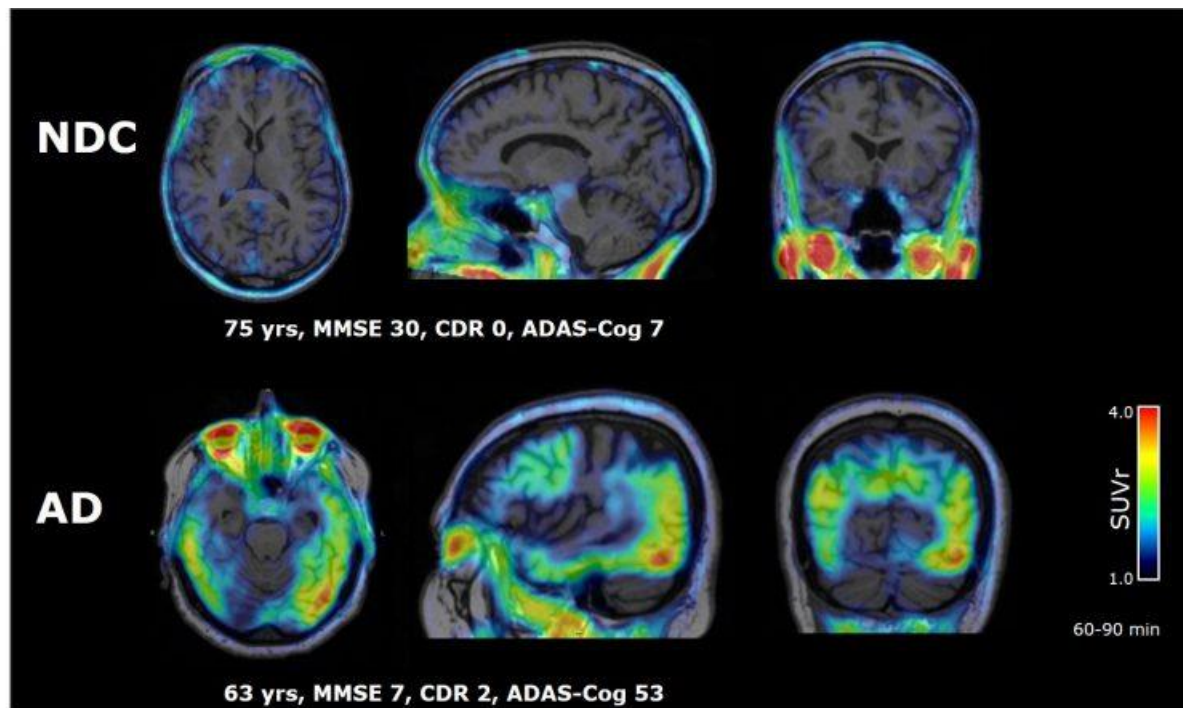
PI-2620 SUVR images of a non-demented control (NDC) and AD subject (60-90 min p.i. using cerebellar cortex as reference region)
